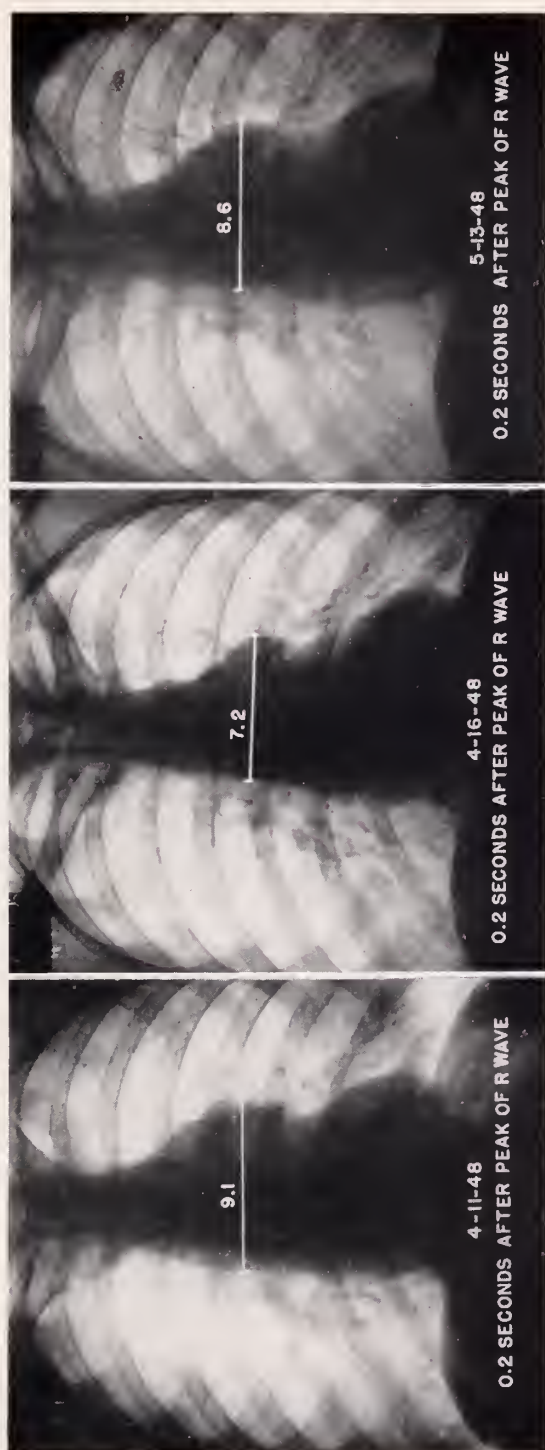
Roentgenograms made during the same phase of the cardiac cycle (mid-systole) and respiration.
